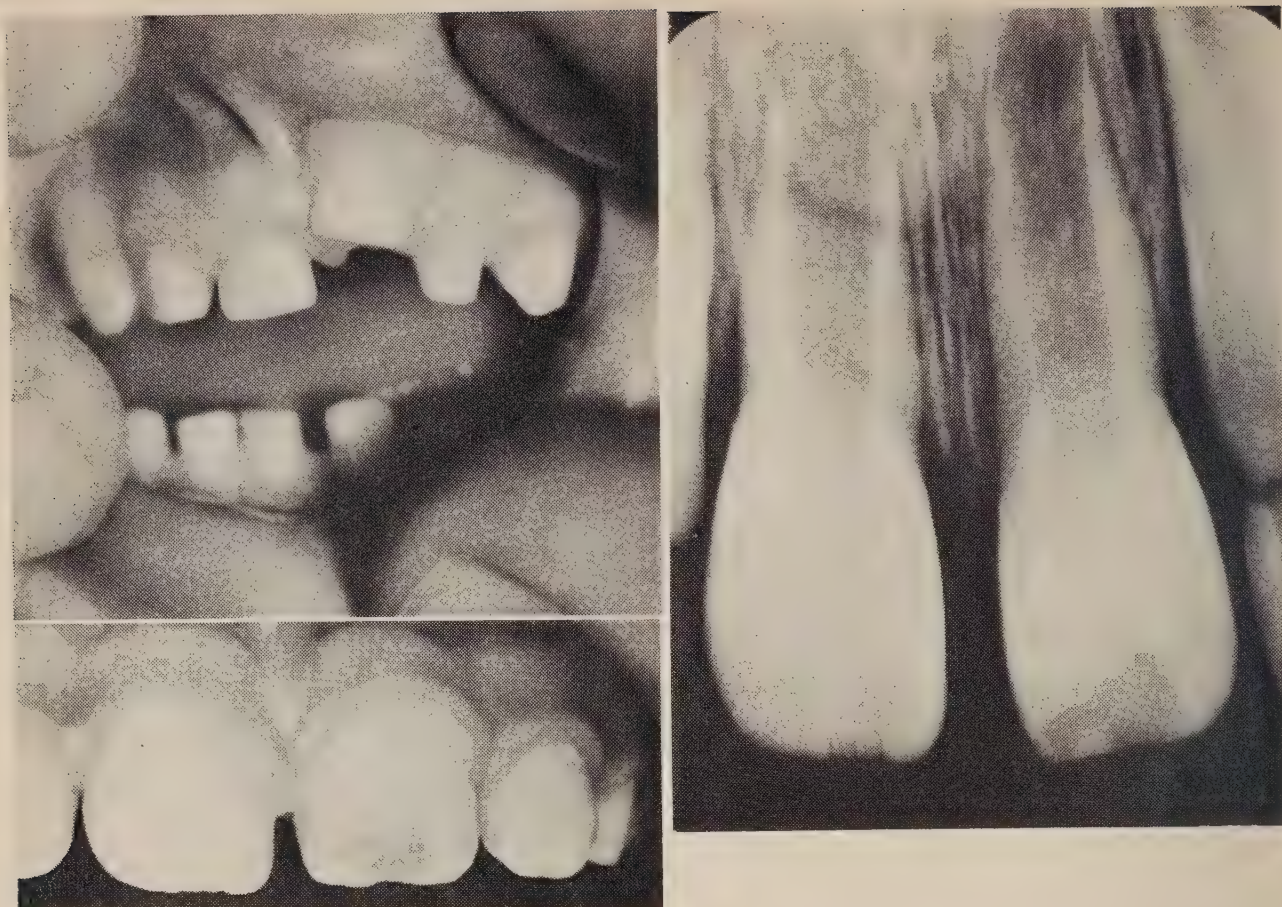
Accidental intrusion of a deciduous incisor. Above left: the upper left deciduous central incisor was allowed to remain and permitted to erupt again. Right: radiograph shows a radiolucent area in the upper left permanent central incisor. Such defects can be detected radiographically before the tooth erupts. Below left: the disfigured hypoplastic permanent tooth. Only the enamel and outer layer of dentine are affected.
